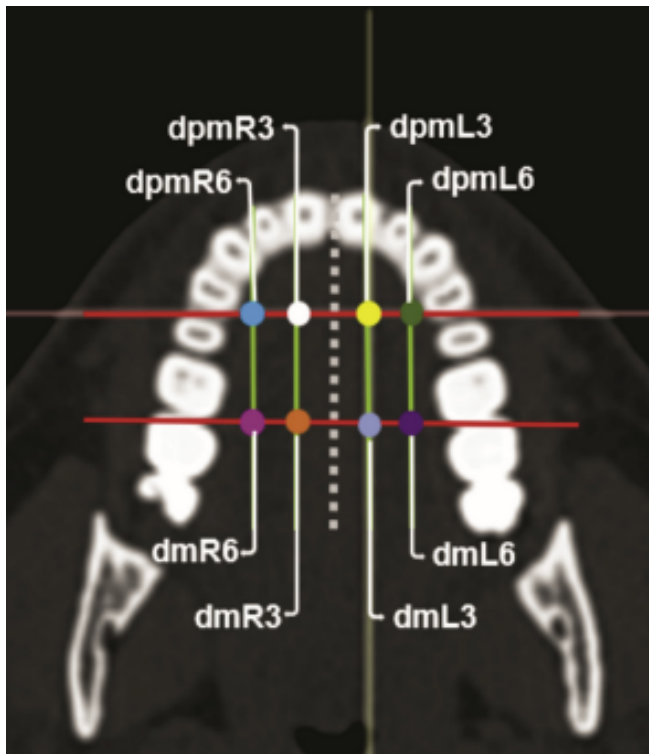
Axial slice CBCT, reference points constructed to measure the palate thickness and the optimal mini-implant zone insertion, with distal face of the left first premolar at 3 mm from the midpalatal suture (dpmL3) (10).
